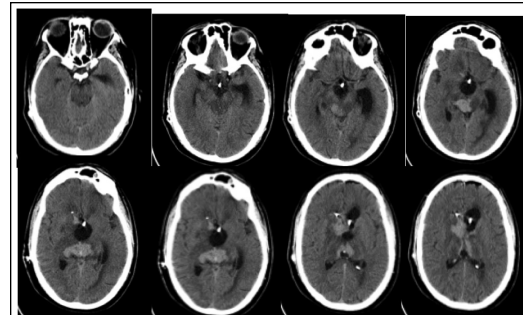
Post-operative CT-scan showing the correct placement of a multifenestrated catheter into the ventricular system in the same cases with the Seldinger Technique.
